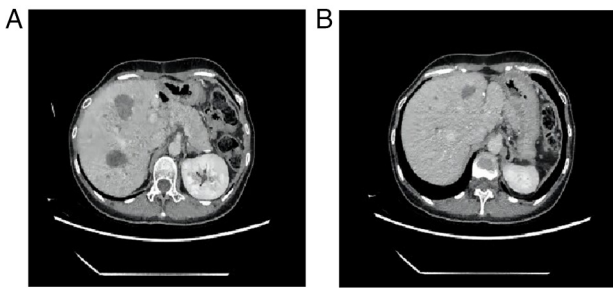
CT (enhanced) acquired at postoperative month 10. (A and B) CT images of multiple liver lesions after treatment. CT, computed tomography.
